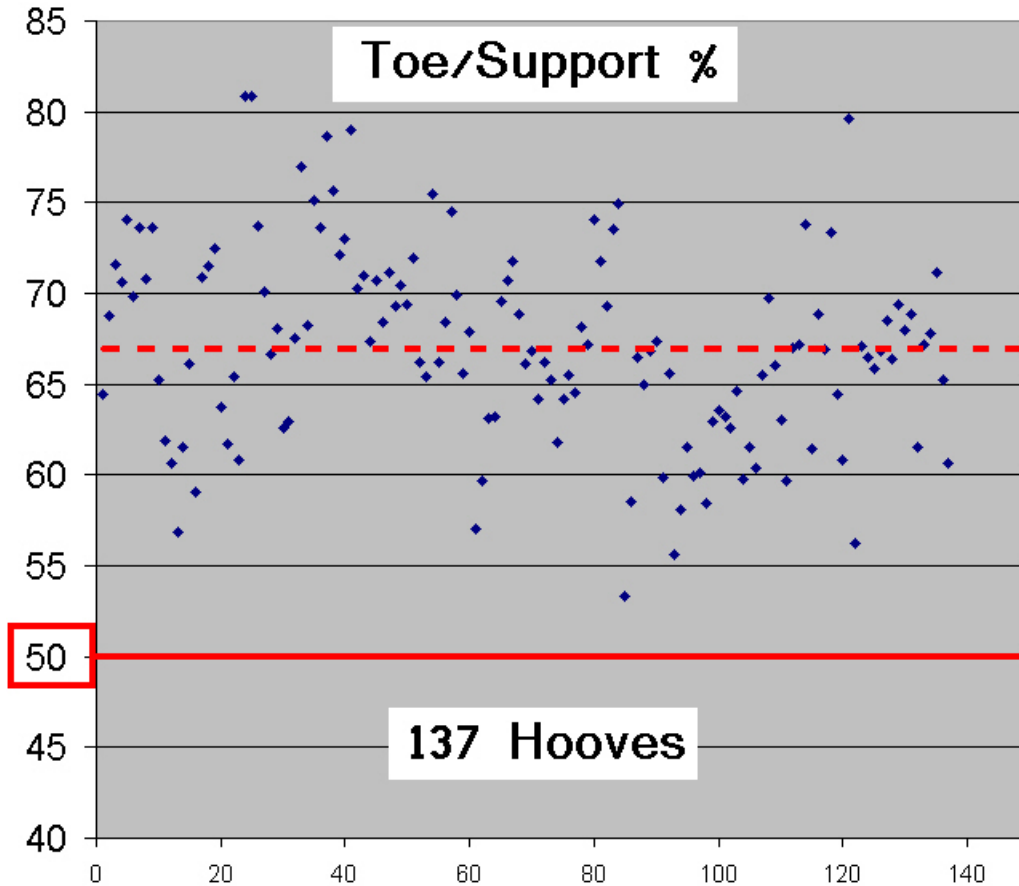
The “Toe/Support %” is the percentage of the ground support line that is forward of the coffin-joints center of articulation as viewed in a lateral radiograph.
